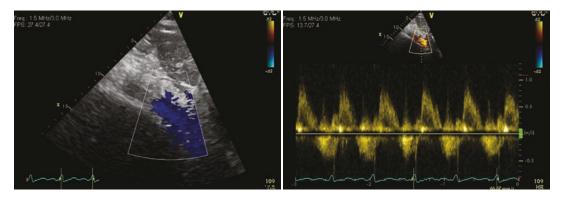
Diastolic flow reversal in the abdominal agrta taken from the subcostal window. Note the holodiastolic flow reversal on PW doppler (below the line)
